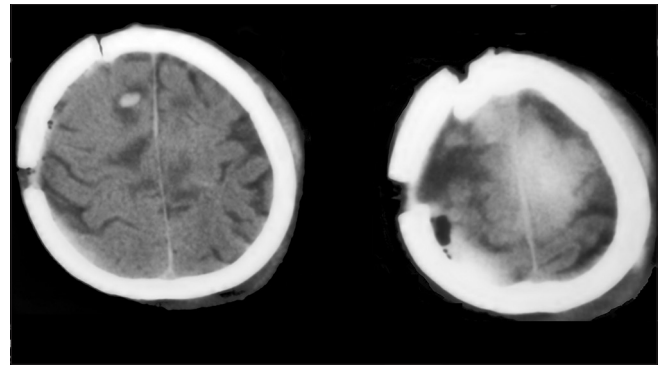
Postoperative computed tomography scan showing residual vertex extradural hematoma
